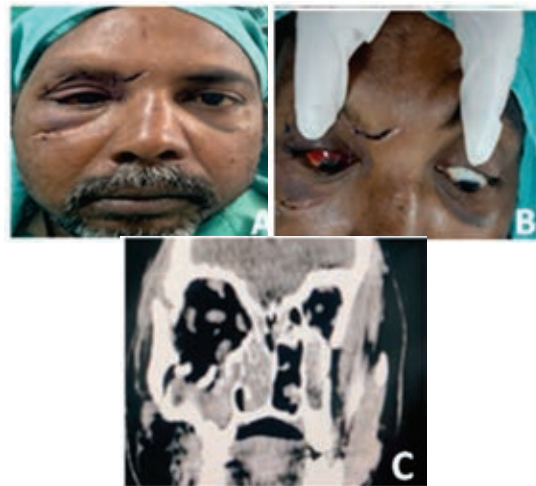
(A) Right eye Enophthalmos with sub conjunctival hemorrhage and Ecchymosis with sutured lid laceration, (B) limitations of Right eye depression on downgaze, (C) CT orbit of the same patient with fracture of the right eye orbital floor and lateral wall
